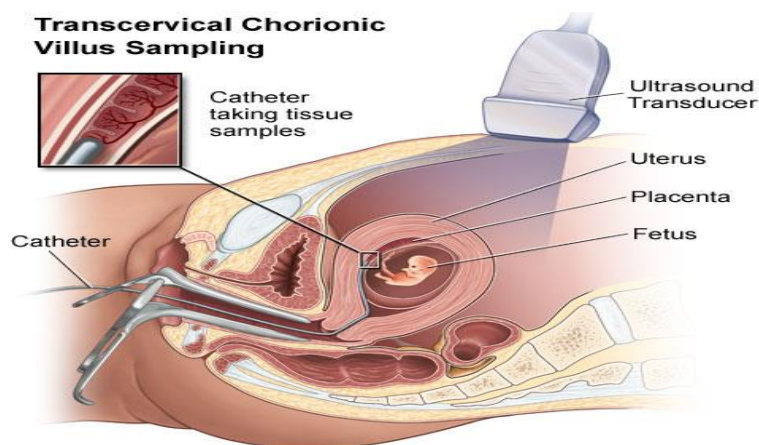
Transcervical CVS. A catheter is inserted through the vagina and cervix, and guided towards the placenta using the ultrasound scanner. The catheter will then collect tissue samples from the placenta.⁵⁵
